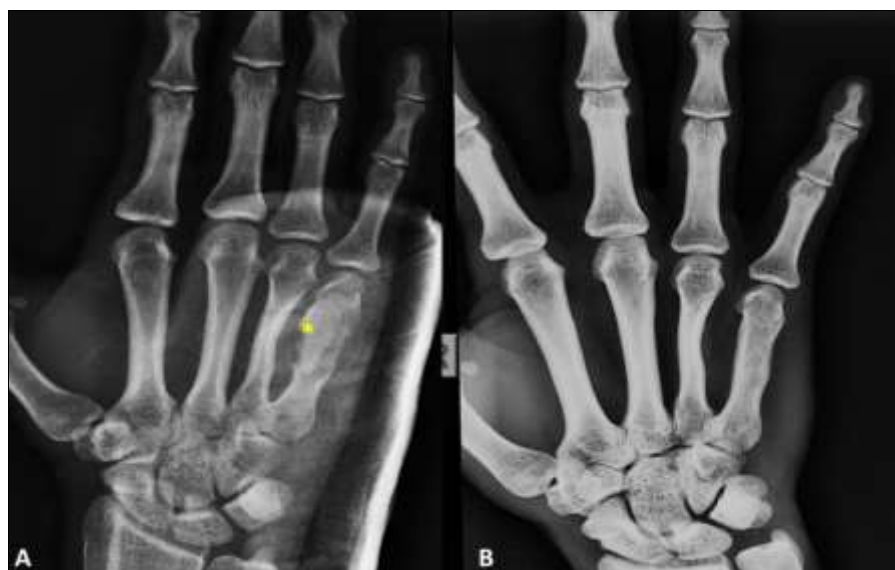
Postoperative Imaging. A. Early post-operative X-Ray shows bone graft (Yellow asterisk) is distinguishable from the surrounding cortical shell at meta-diaphyseal region of 5th metacarpal. B. Bone union with successful graft integration has been achieved at the 6-month follow-up.
